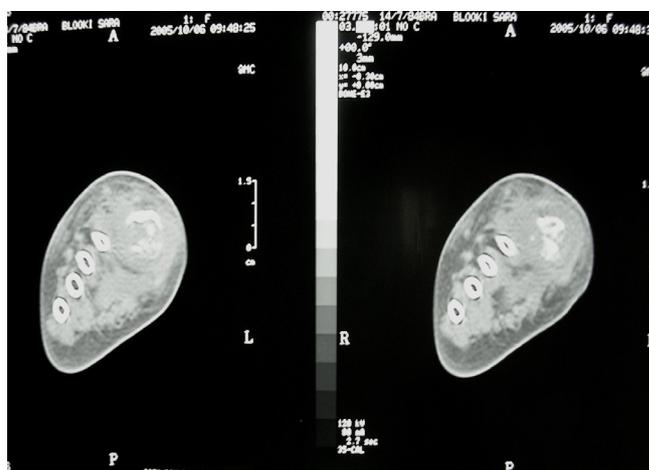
Axial CT-scan of first metatarsal cortical destruction.
